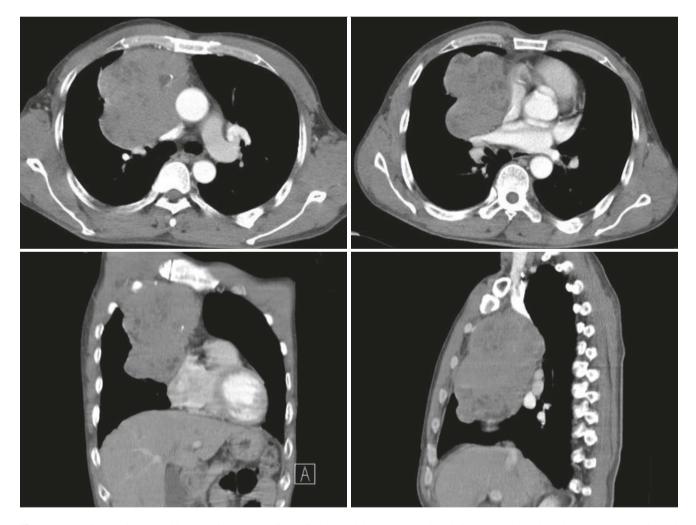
A 56-year-old man with type B2 thymoma. Chest CT showed that the tumor invaded the capsule, and cystic changes, necrosis, and calcification were seen in the lesion
